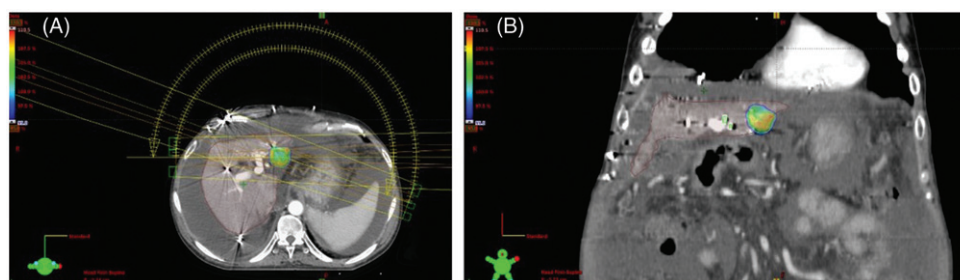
Planning 4D-CT with radiation dose plan. Axial (A) and coronal (B) views. Liver, outlined, surrounded by ascites. ITV is shaded in right liver lobe. Bullet fragments used as fiducials are shaded, just adjacent to ITV in coronal view. ITV: internal target volume.
